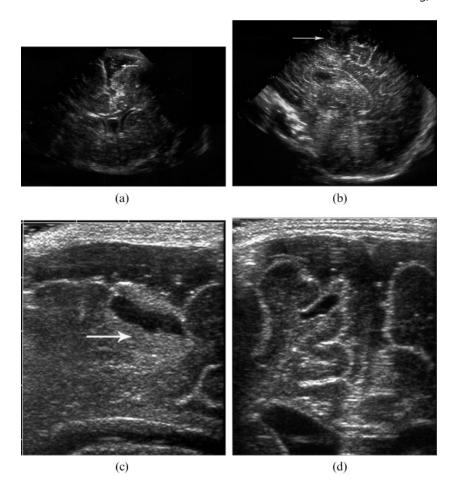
Ultrasound appearances of cortical tears. (a,b) Case 1. Cortical tear in left superior frontal gyrus. The adjacent brain parenchyma is mildly hyperechogenic on the coronal image. (c,d) Case 4. Hypoechoic cortical tear in right superior frontal gyrus. The surrounding parenchyma is hyperechogenic.
